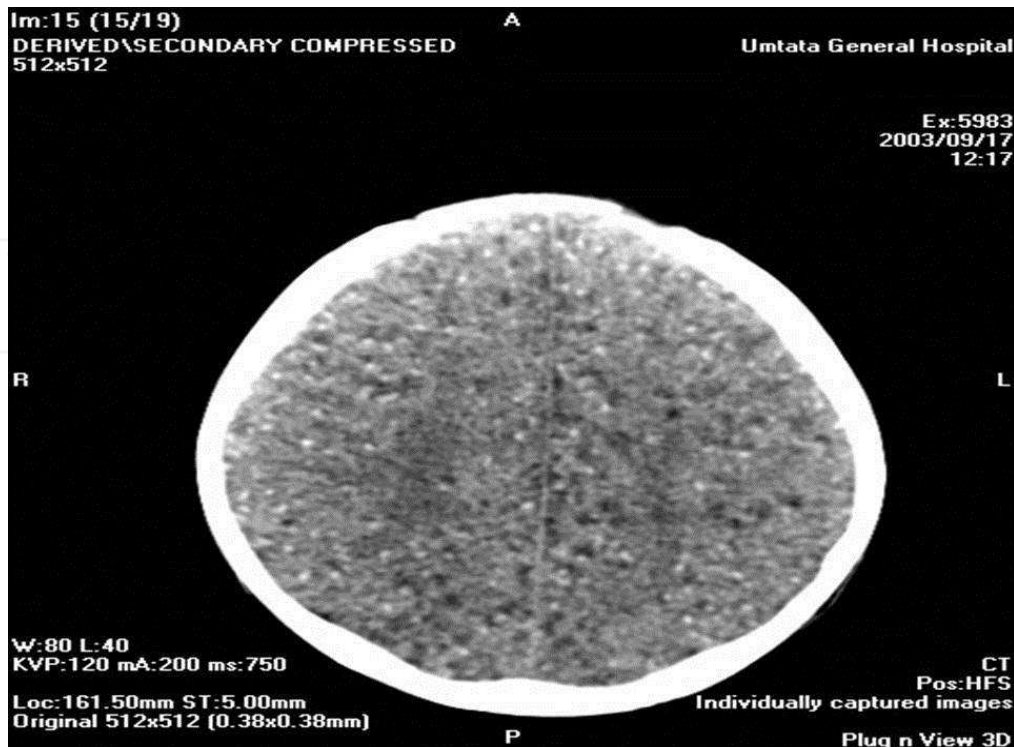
CT scans of the brain show severe NC.
